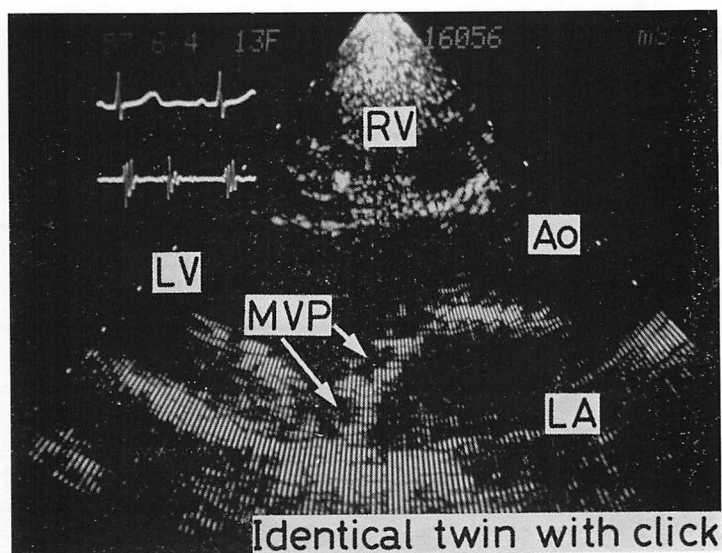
Two-dimensional echocardiograms of the first twin.
